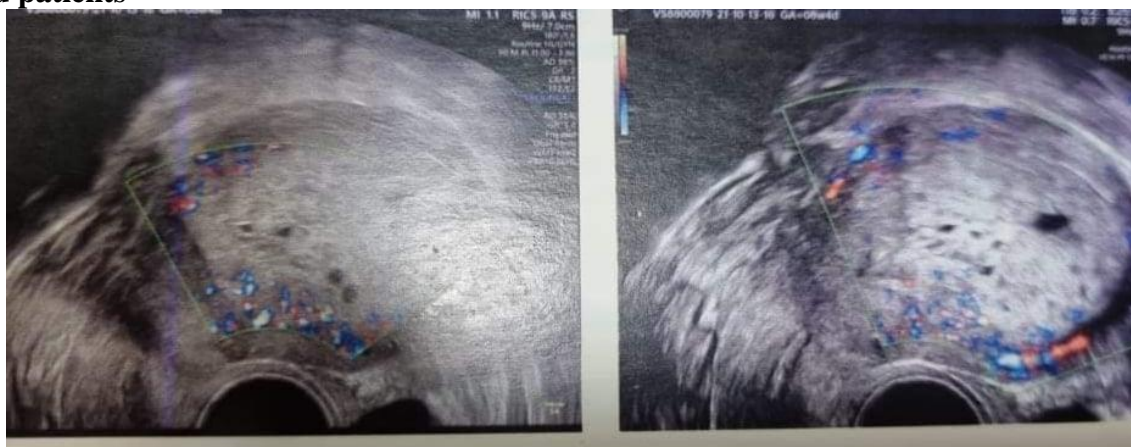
Doppler ultrasound showed Complete mole with honeycomb appearance
